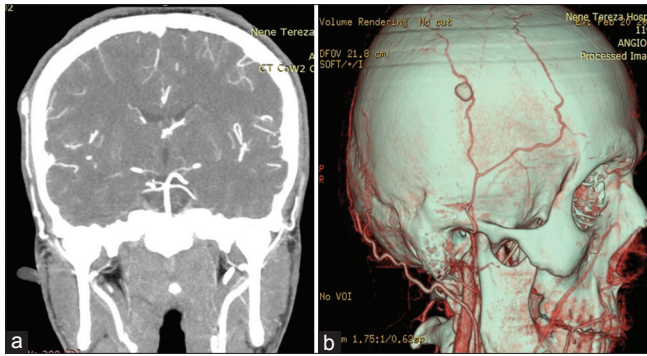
(a) (left inset) Enhanced computed tomography (CT) demonstrating a small mass in the right temporal region. (b) (right inset) CT angiography depicting the pseudoaneurysm in the parietal branch of the right superficial temporal artery
